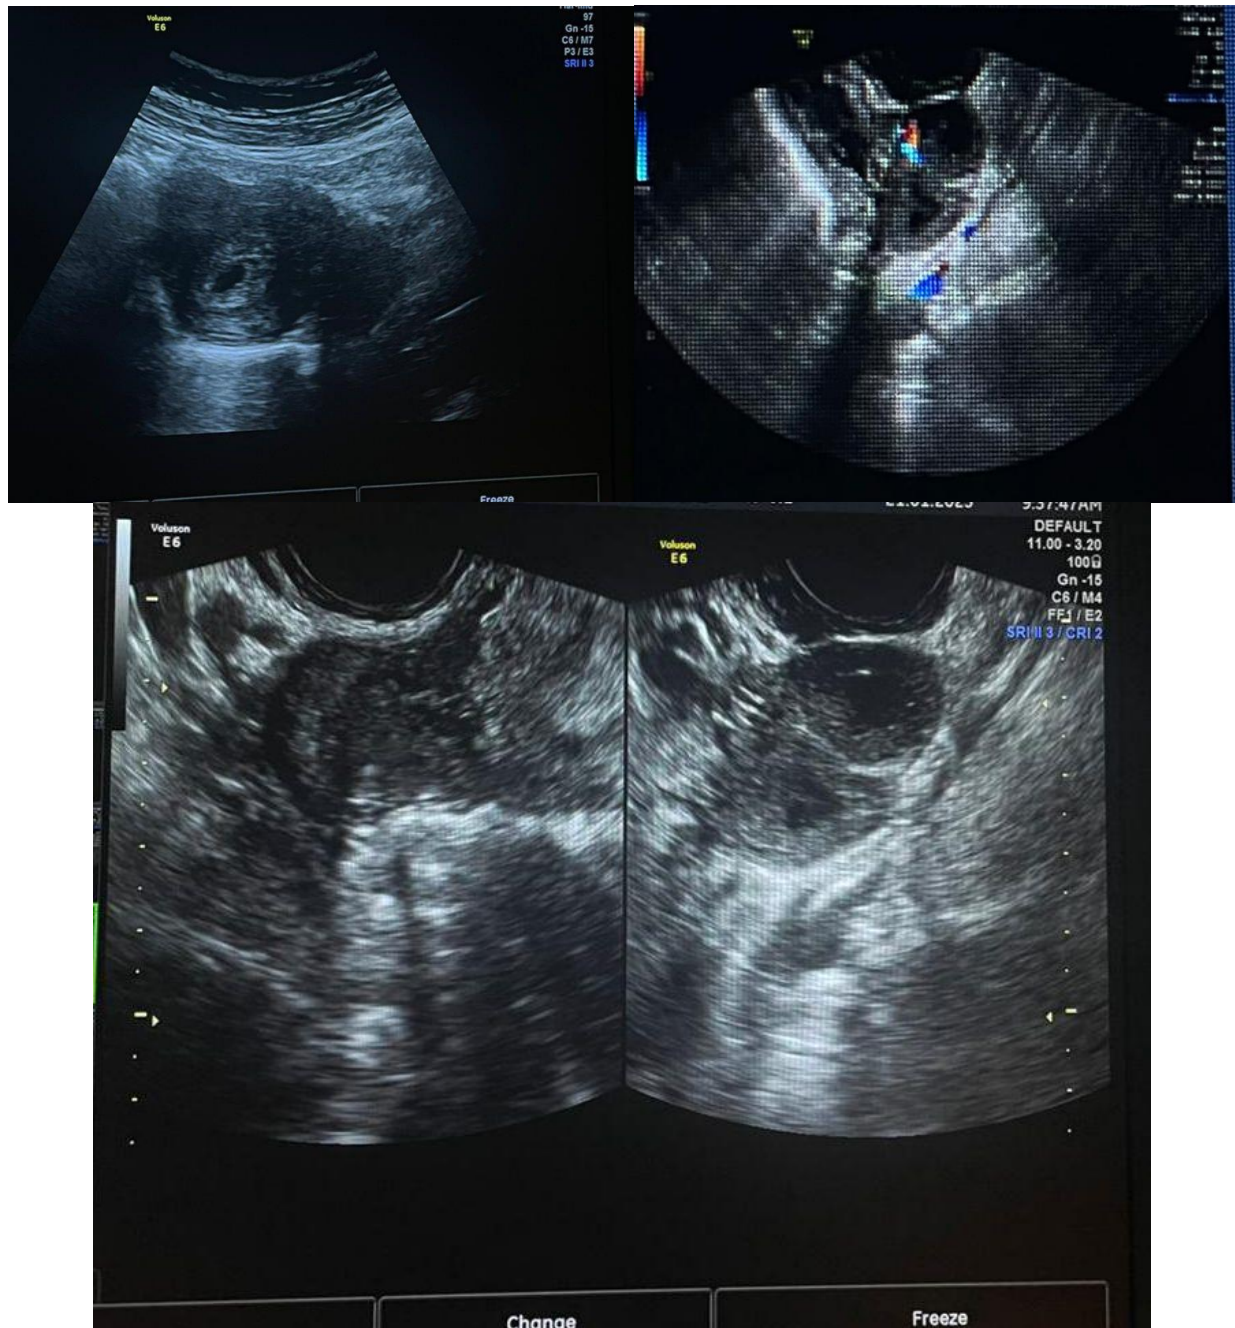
Transvaginal ultrasound - intrauterine elongated gestational sac
